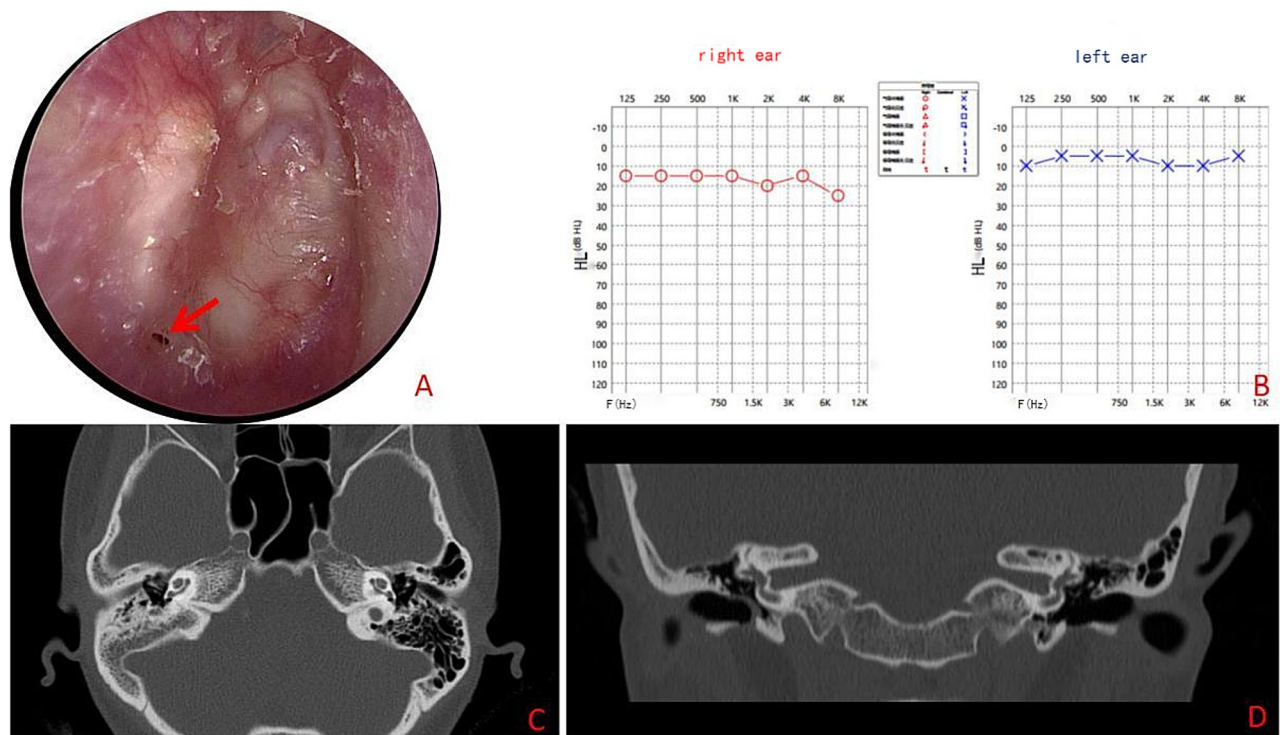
Preoperative assessment data of typical cases. (A) Preoperative endoscope image, with the red arrow indicating the perforated part of the tympanic membrane. (B) Preoperative pure tone audiometry suggests normal hearing in the right ear. (C) Axial temporal bone CT shows air in the tympanic cavity without any abnormal density shadow. (D) Coronal temporal bone CT shows air in the tympanic cavity and an intact ossicular chain.
